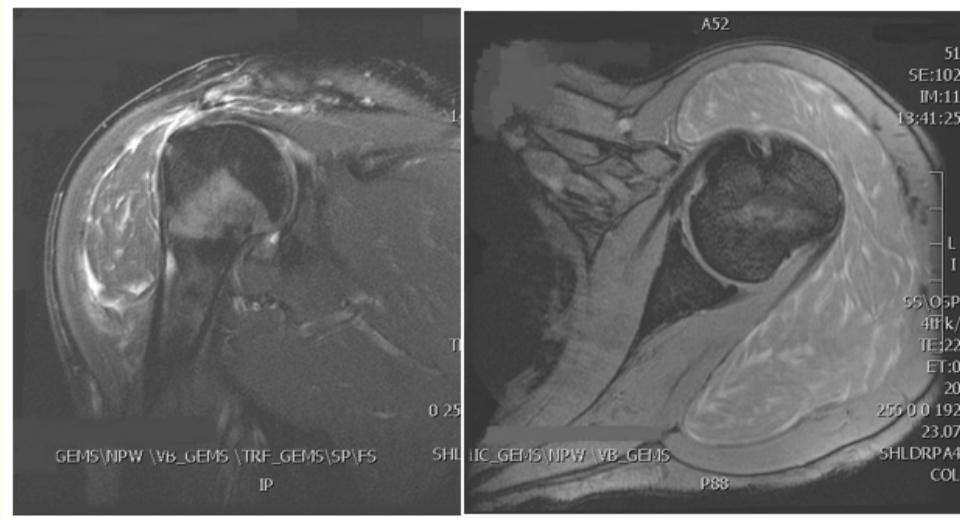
MRI showing areas of signal alteration on the subdeltoid bursa.
